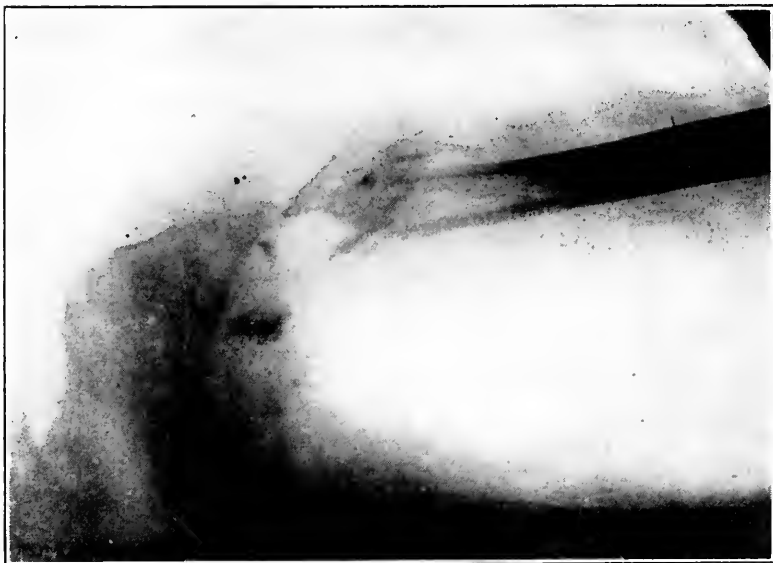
X-ray of compound, comminuted fracture of the humerus, taken four months after gunshot wound. It shows complete non-union, loss of substance of the shaft with separation of the fragments, and the presence of sequestra.
